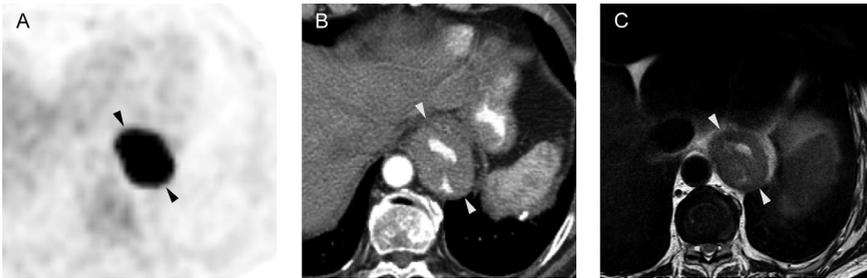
A direct comparison of (A) ^{18}F -FDG PET, (B) CT and (C) MR images in one patient with a cT3N1M0 distal esophageal tumor (*arrowheads*). By providing excellent soft-tissue contrast MRI potentially allows for more precise tumor delineation and radiotherapy planning.
